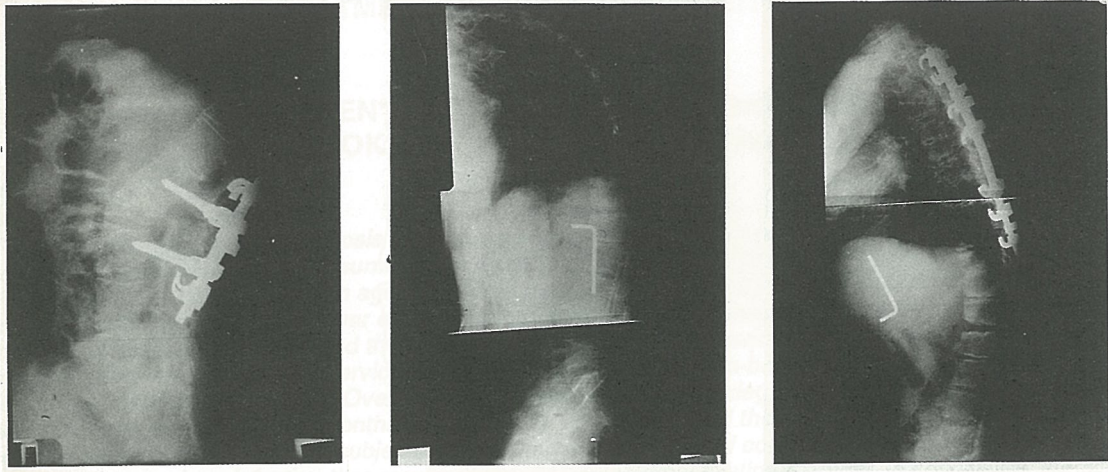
H.A., 37 years old, male, Postoperative roentgenogram.
